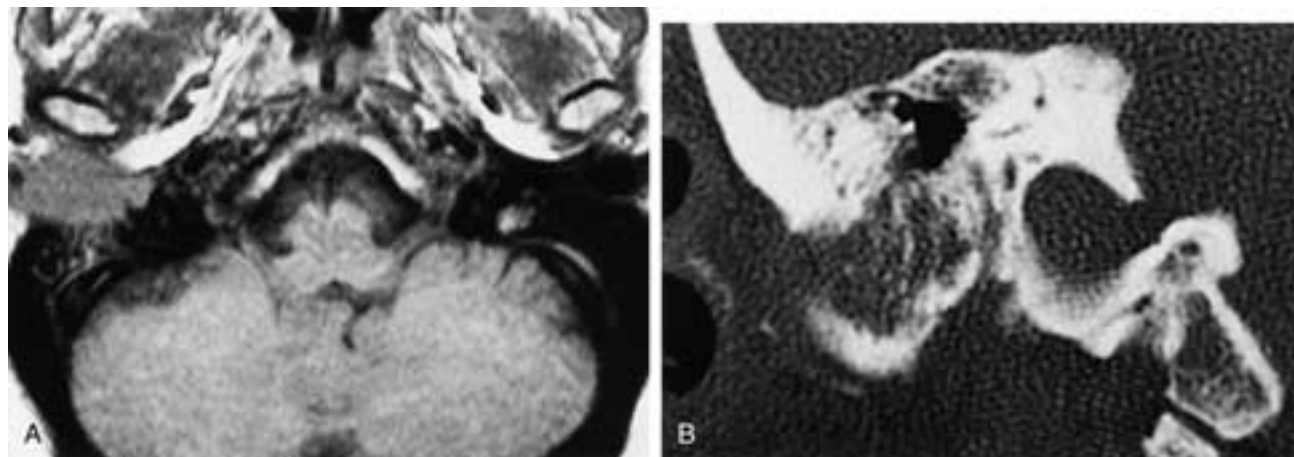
EAC squamous cell carcinoma. A, T1-weighted image shows destruction of the canal wall and extension into the tympanic cavity. B, CT, coronal section, shows extension of tumor into the mastoid process and invasion of the descending nerve canal. (Compare with Fig. 25-115.)
